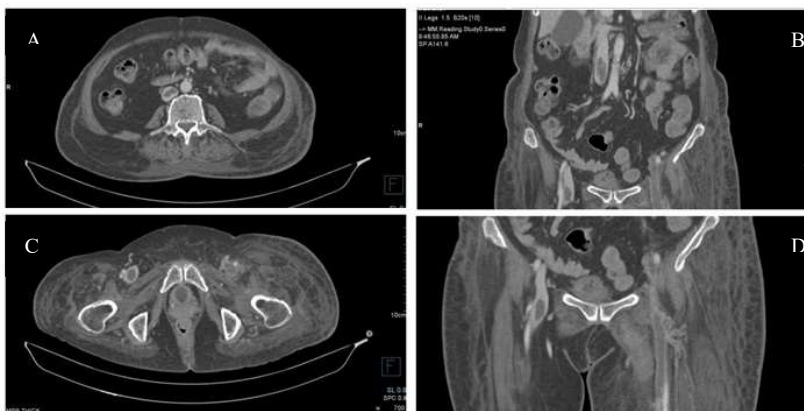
CT peripheral angiogram in both lower limbs(a) and (b) axial and coronal images showing hypodense thrombus at the level of inferior vena cava (infrarenal). (c) axial image showing hypodense thrombus in bilateral common femoral veins. (d) coronal image shows hypodense thrombus in bilateral common femoral veins and left superficial femoral vein.
